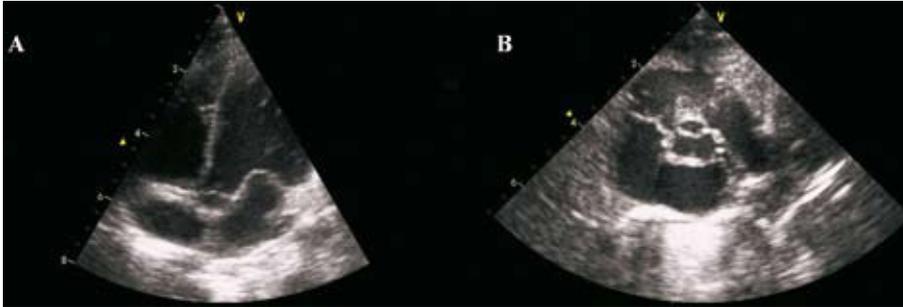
Echocardiographic examination 6 weeks later with views that are superimposable on Figure 1, showing total spontaneous regression of the tumorous masses.
